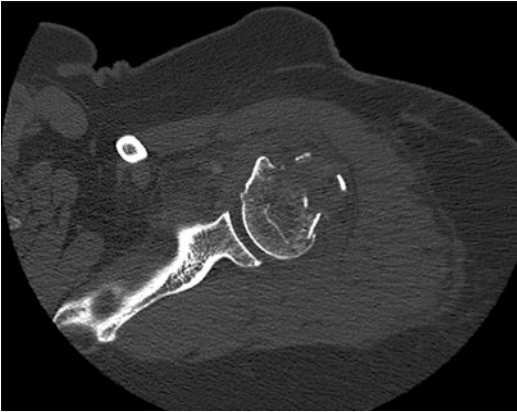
An axial computed tomography scan of the left shoulder demonstrating a comminuted proximal humeral fracture
